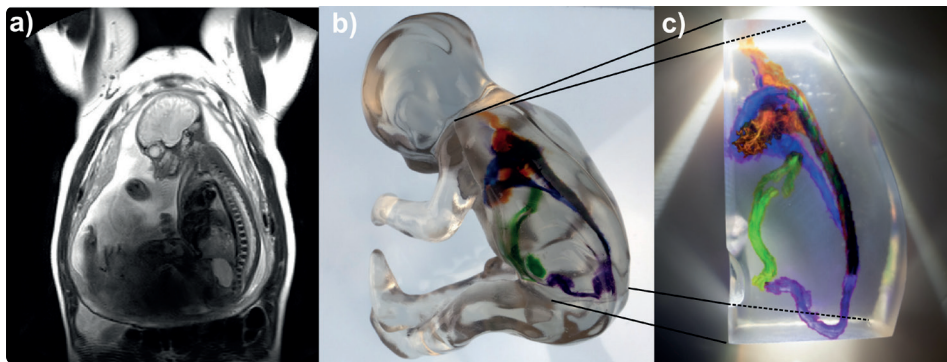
a) T2 weighted single shot fast spin echo localizers were used to obtain the fetal volume and b) 4D flow MRI was fused with the 3D volume. A 3D printed insert c) was created to minimize the optical distortion of the 4D flow MRI data.
